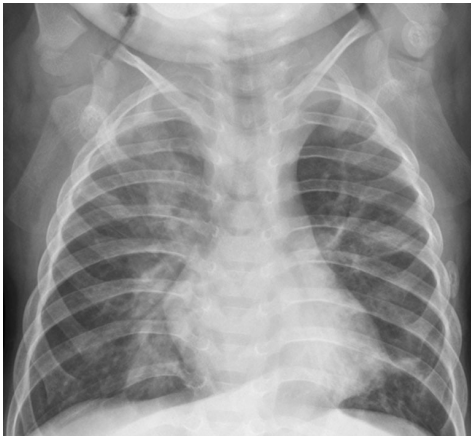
Respiratory syncytial virus bronchiolitis. Anteroposterior radiograph of the chest in a 14-month-old girl with Down syndrome shows symmetrical hyperinflation of the lungs, streaky perihilar opacities and other focal right upper lobe opacities. The girl was diagnosed with respiratory syncytial virus (RSV) bronchiolitis
